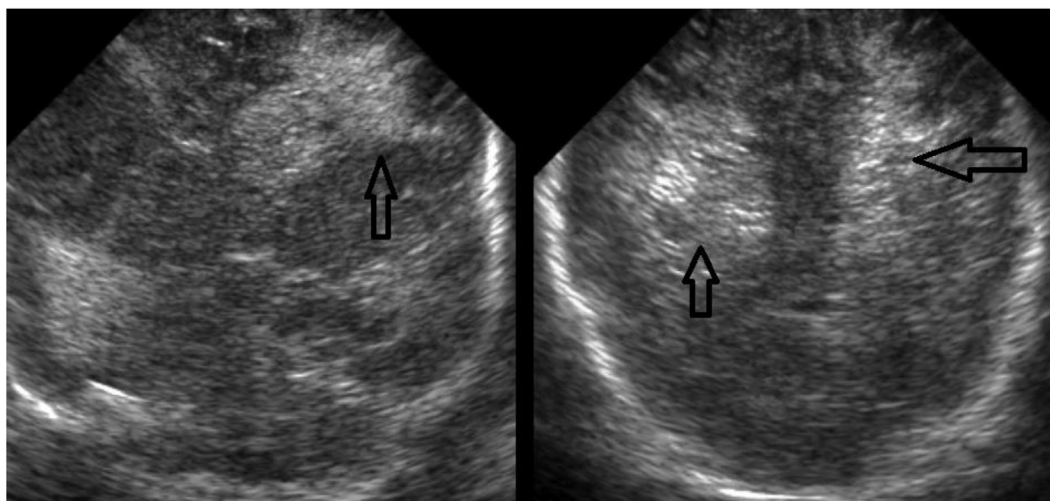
Coronal scans of neonatal brain ultrasound shows periventricular extension of the hemorrhagic changes seen as hyperechoic pattern of the brain parenchyma prominent at the frontal lobe (open black arrows).
